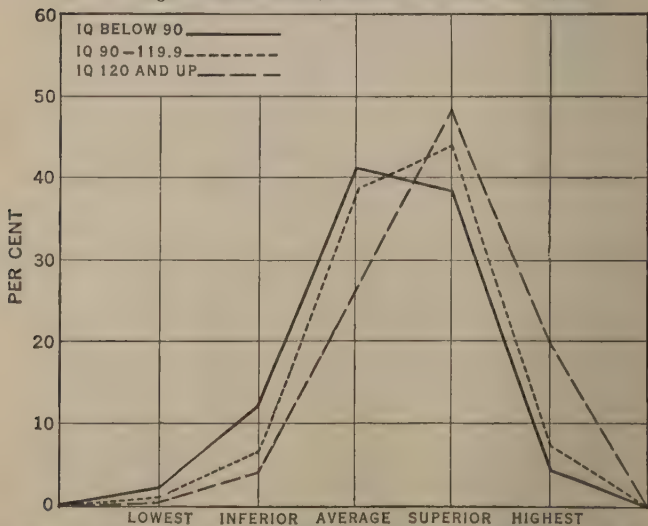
LEVELS OF INTELLIGENCE AND COMBINED RATINGS ON TRUSTWORTHINESS AND RESPECT FOR AUTHORITY
